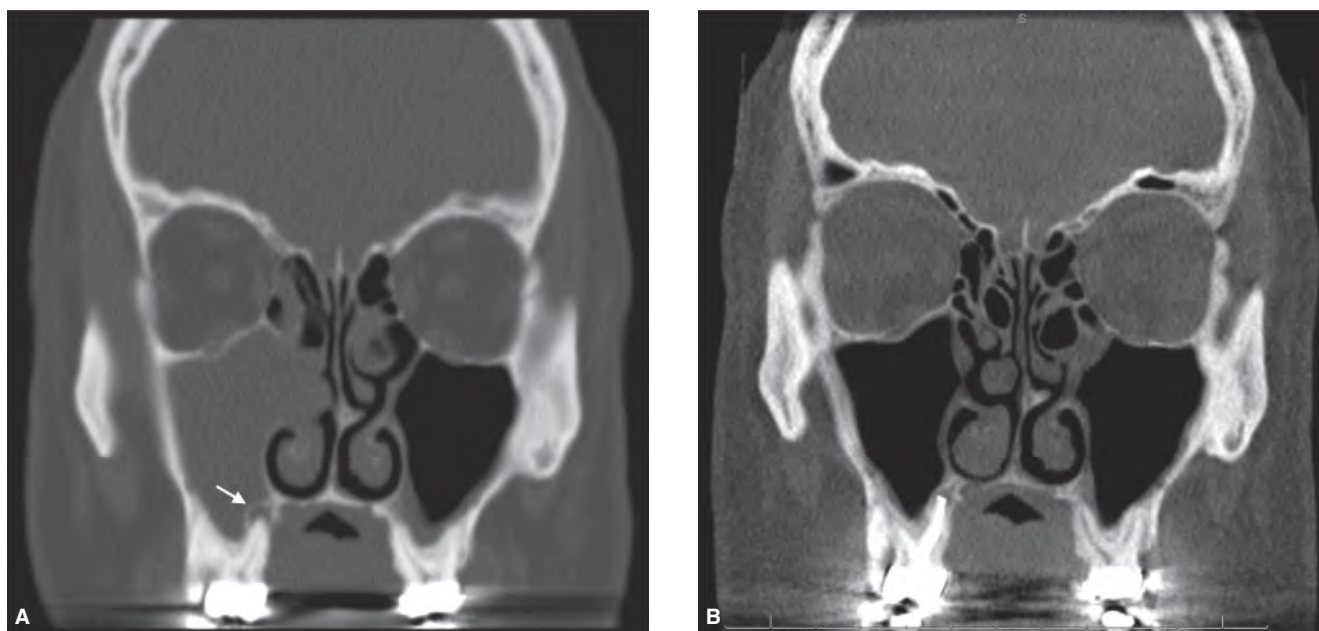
Odontogenic rhinosinusitis. A. Coronal CT image of a fully obstructed right maxillary sinus. The patient had experienced recurrent right maxillary sinus infections and nasal obstruction for more than 4 years with no resolution, despite multiple antibiotic regimens and adjunctive sinus treatments. An associated periapical osteoperiostitis lesion is evident over the palatal root apex of the maxillary right first molar (arrow). B. Three-month postoperative coronal CT image showing full resolution of the maxillary rhinosinusitis following endodontic treatment of the maxillary first molar. No other sinus treatment was performed nor antibiotics administered.
